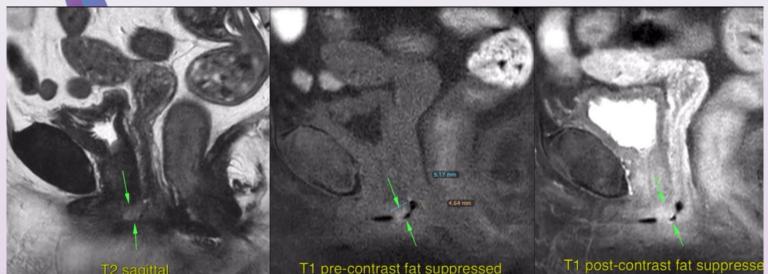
MRI pelvis demonstrating localised urethral mass
